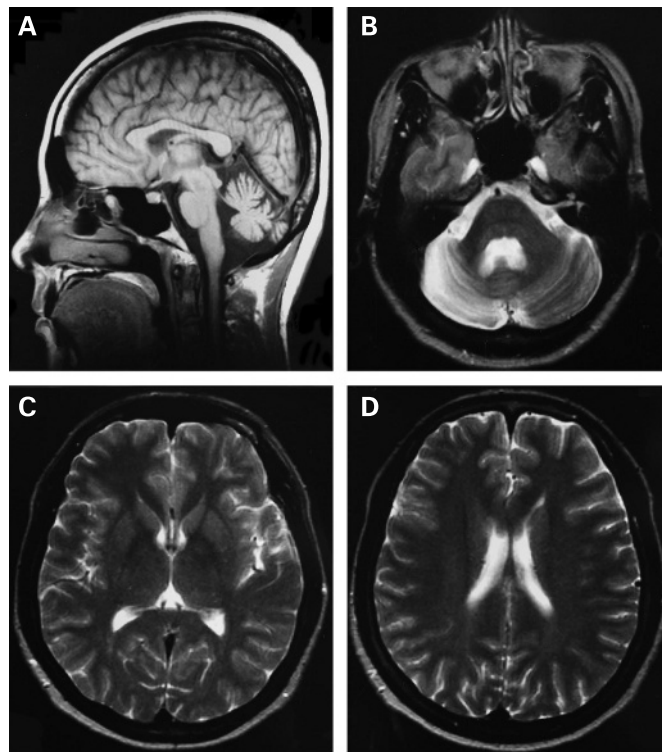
Representative MRI of patient 10. (A, B) T₁-weighted sagittal MRI (TR = 600, TE = 15) and T₂-weighted axial image (TR = 5000, TE = 22) taken 20 years after poisoning revealing a moderate degree of cerebellar atrophy. (C, D) Basal ganglia and cerebral hemispheres on T₂-weighted axial images showing no abnormality (TR = 5000, TE = 90).
